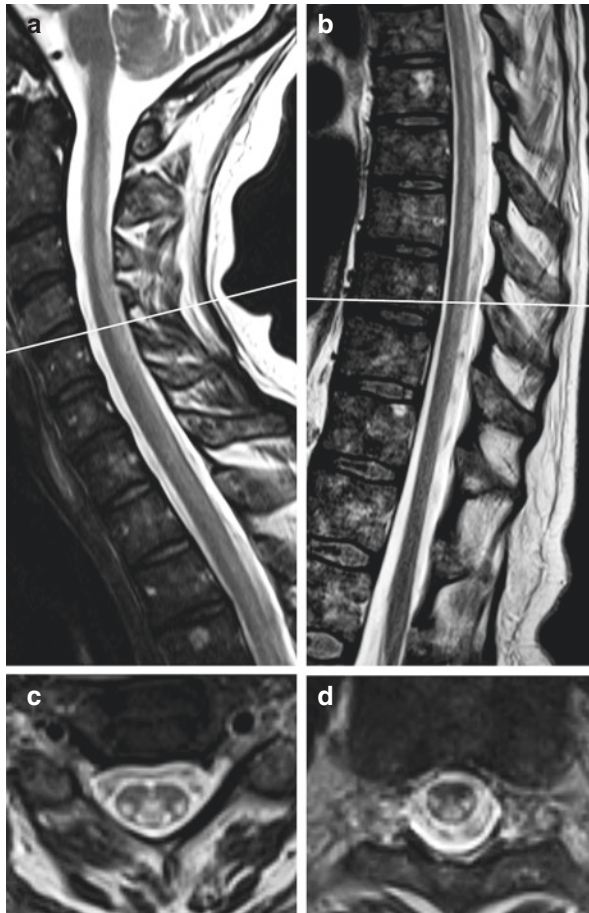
HIV myelopathy. T2-weighted (a) cervical and (b) thoracic spinal MRI of a 43-year-old woman with a known HIV infection and a progressive paraparesis and gait ataxia are shown. (c, d) Note the longitudinal hyperintensities along the complete spinal cord with a restriction to the lateral and posterior cord. Lines indicate the sectional plane position of the axial images. Gadolinium enhancement was not found (images not shown) (Images courtesy of Dr. Peter Raab, Neuroradiology, Hannover Medical School)
